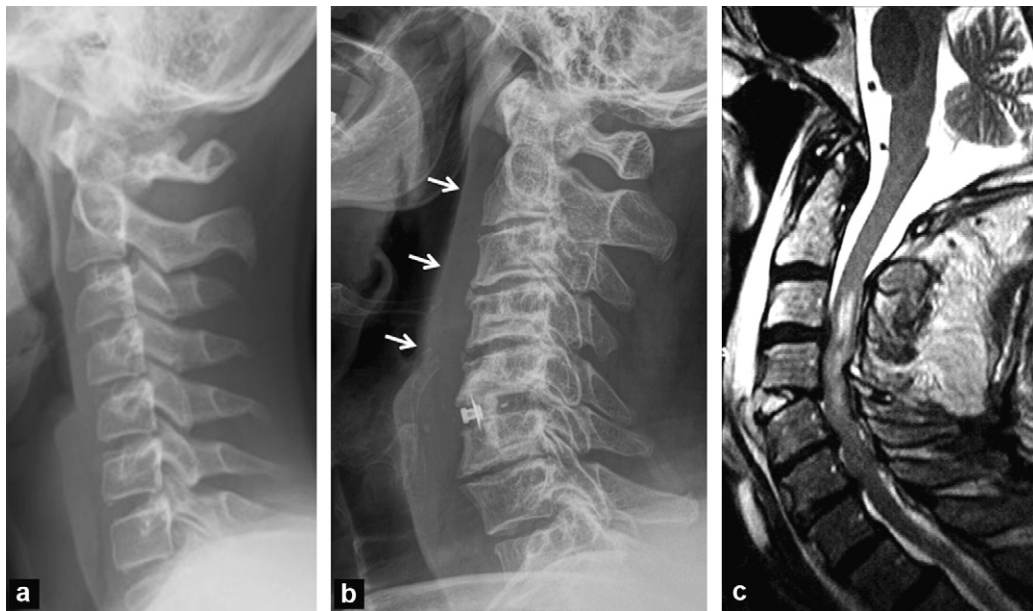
Study of the pre-vertebral soft tissues. a: normal X-ray. The soft tissues are concave towards the front above and at the level of C2 and the thickness is inferior that of the base of the odontoid process; thickness less than 7 mm from the anterior-inferior corner of C2 to C4; less than 21 mm below that of the adult; b: post-traumatic X-ray: pathological thickening of the soft tissue without obvious bone lesion; c: sagittal T2 weighted MRI (in another patient) shows the interruption of the anterior common vertebral ligament, a discal fracture with hypersignal and an intra-medullar hypersignal. Also posterior impairment with hypersignal of the ligamentum flavum and of the soft tissues behind the spine.
